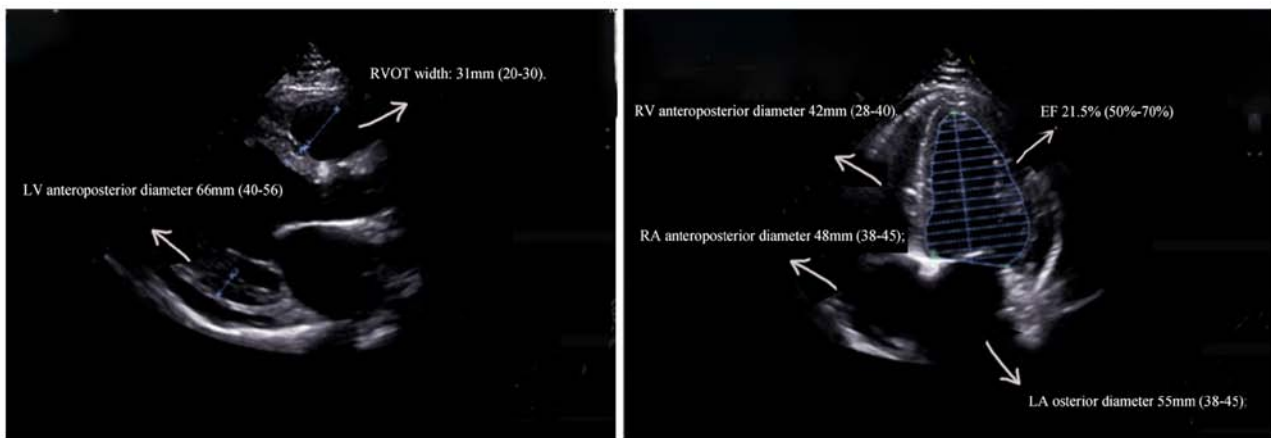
Echocardiography showing that the whole heart was enlarged. LVEF, left ventricular ejection fraction; LA, left atrial; RA, right atrial; RVOT, right ventricular outflow tract.
